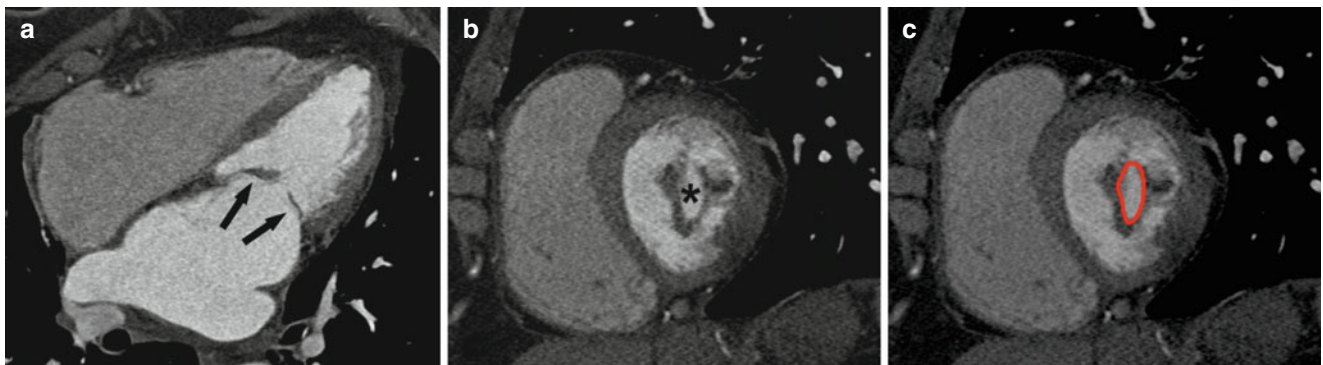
Contrast-enhanced CT scan in the four-chamber and short-axis views (panels a and b, respectively) from a patient with rheumatic mitral stenosis. The typical thickening and restricted dome-shaped
